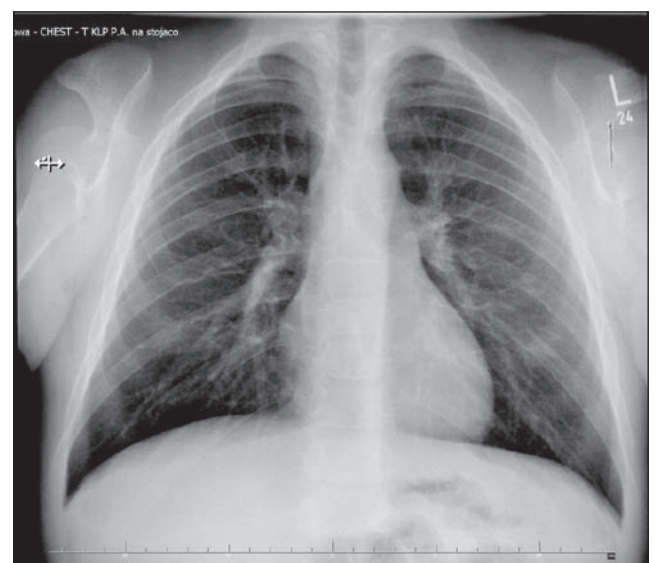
Chest X-ray confirming the lack of clavicles.
